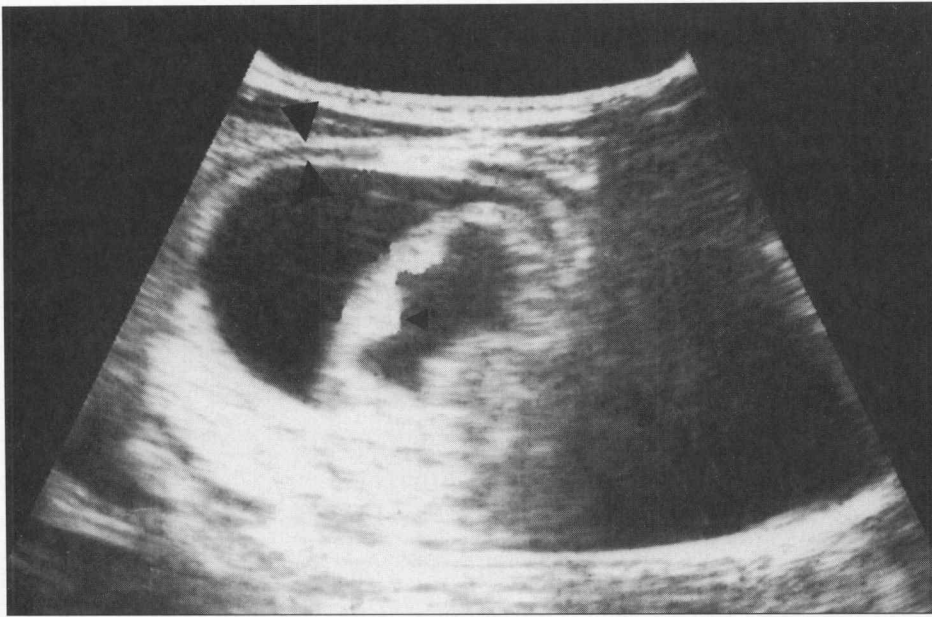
Same ultrasonogram as in Figure 1. Notice the 2 concentric hyperechoic rings, which represent the intussusceptum (small arrowheads) and intussusciens (large arrowheads).
